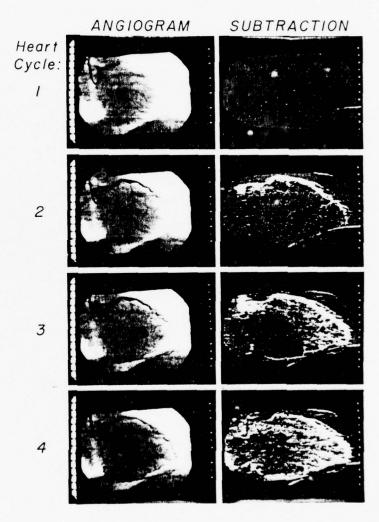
X-ray video images of human heart (left column) recorded at same phase of diastole in 4 successive cardiac cycles during selective coronary angiography, and computer-generated difference images of the heart (right column) determined by dynamic background subtraction for this same phase of these 4 cardiac cycles before, during, and following injection of x-ray contrast material into the left anterior descending coronary artery.
